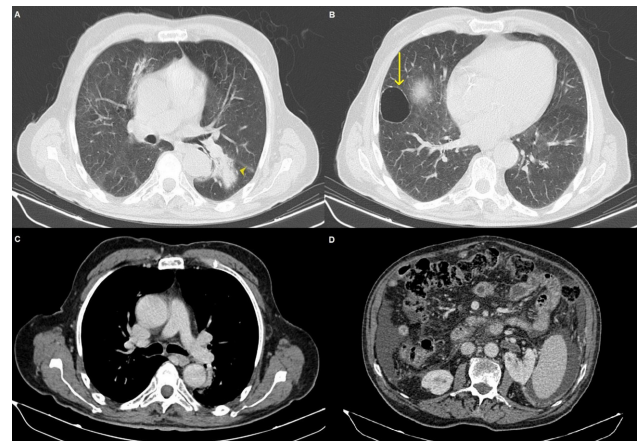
Axial CT images obtained three months later demonstrate persistent pulmonary abnormalities without significant interval change. (A, B) Areas of consolidation (arrowhead) associated with pulmonary cysts (long arrow). (C) No mediastinal lymphadenopathy is identified. (D) No abdominal lymphadenopathy is seen; a small volume of ascites is present. The absence of nodal or other extrapulmonary lymphomatous involvement supports the diagnosis of primary pulmonary lymphoma.
